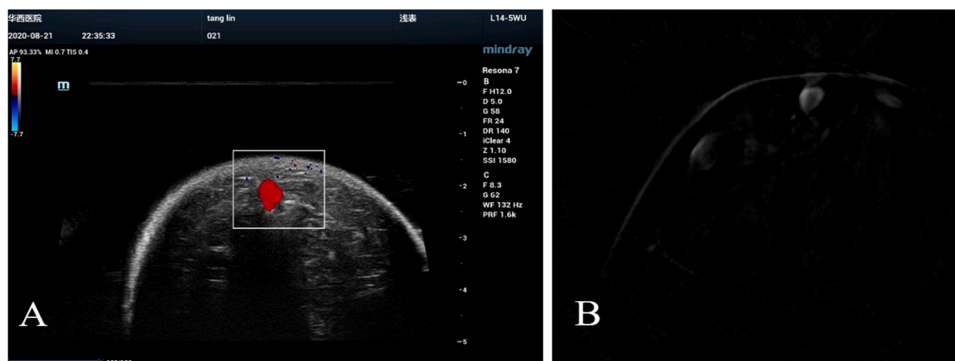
Ultrasound A and photoacoustic B images of the volunteer's blood vessel (indicated by white dashed box).
